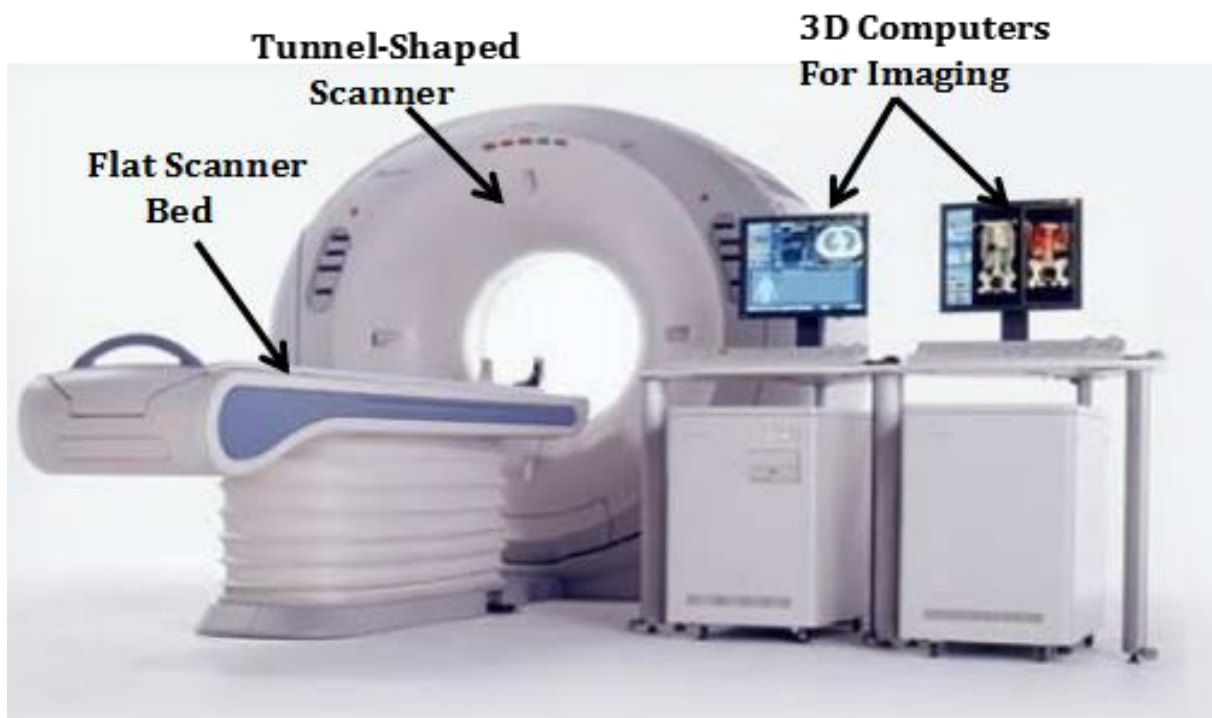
Components of a CT scanner (Andrew, 2023).
